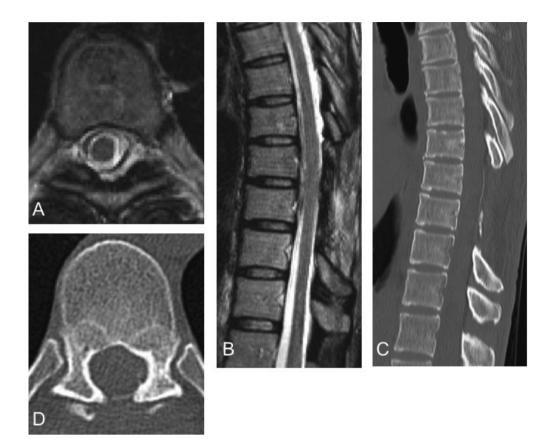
Axial (A) and sagittal (B) T2-weighted postoperative MRI of the thoracic spine shows tumor was removed. Postoperative CT (C, D) shows polytetrafluoroethylene sheet was patched.
